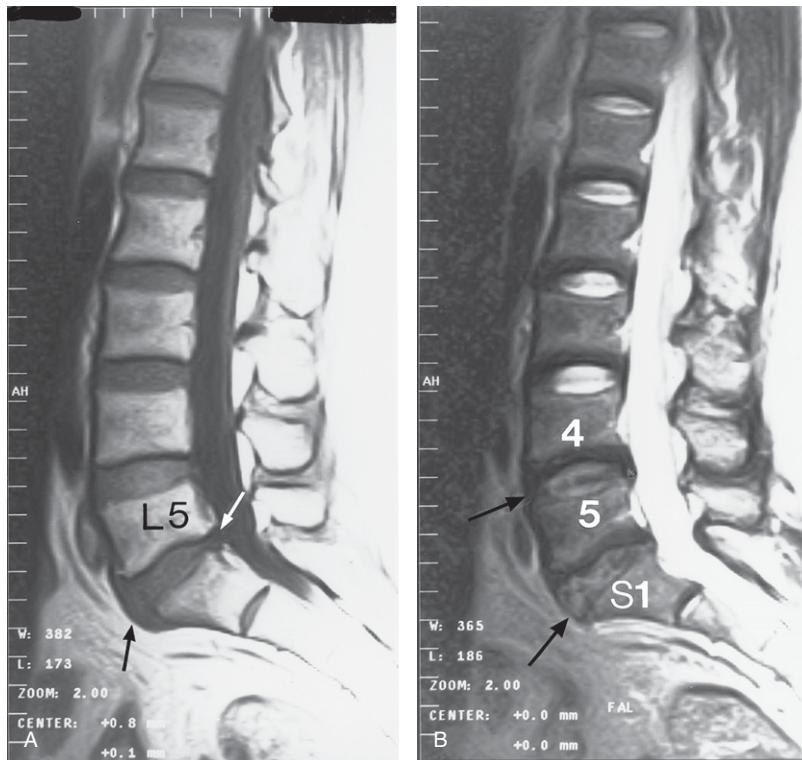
(A) Lumbosacral spine MRI sagittal T1-weighted image showing the large anterior (black arrow) and small posterior (white arrow) disc bulges at the L5–S1 level. (B) Lumbosacral spine MRI sagittal T2-weighted image showing considerable desiccation of the L4–5 and L5–S1 discs (arrows) which have become quite dark in colour compared to the discs above, which have a normal grey colour with a normal black line through them, i.e. the intranuclear cleft.
